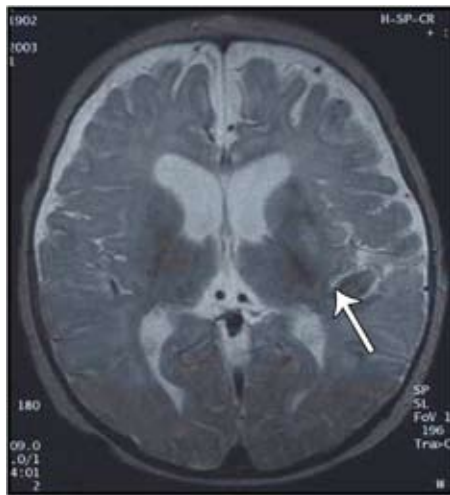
Brain MRI-T2 image which showed a hyperintense signal involving the left temporo-parietal area with caudate and putamin nuclei (arrow).
